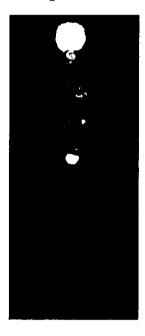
FDG-PET findings in a healthy child. Despite no abnormal inflammation, accumulation in the brain, heart, bladder, and joints at the growth stage is observed.
